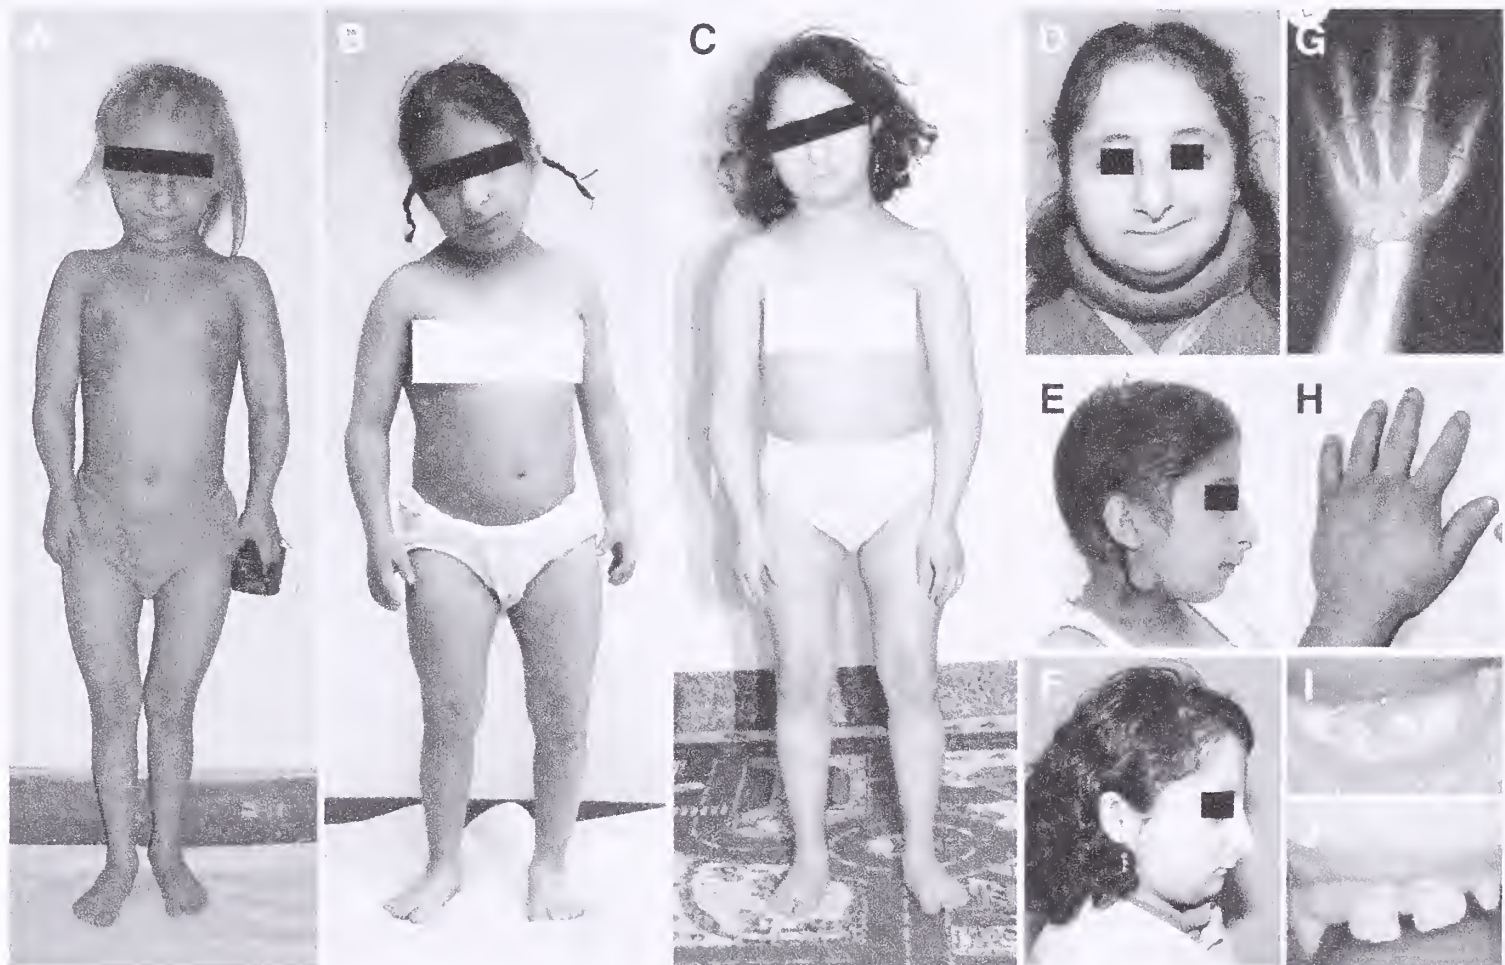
Phenotype of MOPD II patients. (A) P18 at age 8 years 3 months with a height of 84 cm corresponding to a normal size for a female infant aged 1 year 3 months; (B and E) P1 at age 8 years 8 months with a height of 85 cm; (C and F) P2 at age 12 years 6 months with a height of 95 cm and at age 14 years with a height of 96 cm (D) corresponding to a normal size for a female aged 3 years. Note short lower arms especially in P18, mild truncal obesity and premature puberty in P1, significant facial asymmetry in P2 (D), and absence of a sloping forehead typical of microcephaly syndromes. All three patients demonstrate a long nose with prominent tip and hypoplastic alae and small mandible described as typical for patients with MOPD II. (G and H) X-ray and an image of the dorsum of the left hand of patient P2 showing generalized brachydactyly with diaphyseal constriction (overmodeling) of metacarpals and phalanges, as well as abnormal flat shape of the distal radius and ulna epiphyses. (I and J) Hypoplasia and partial agenesis of teeth from patient P2, enamel hypoplasia in teeth from patient P18. Reprinted with permission Rauch A. Science. 2008;319:816-9. Copyright © AAAS 2008. All rights reserved.
